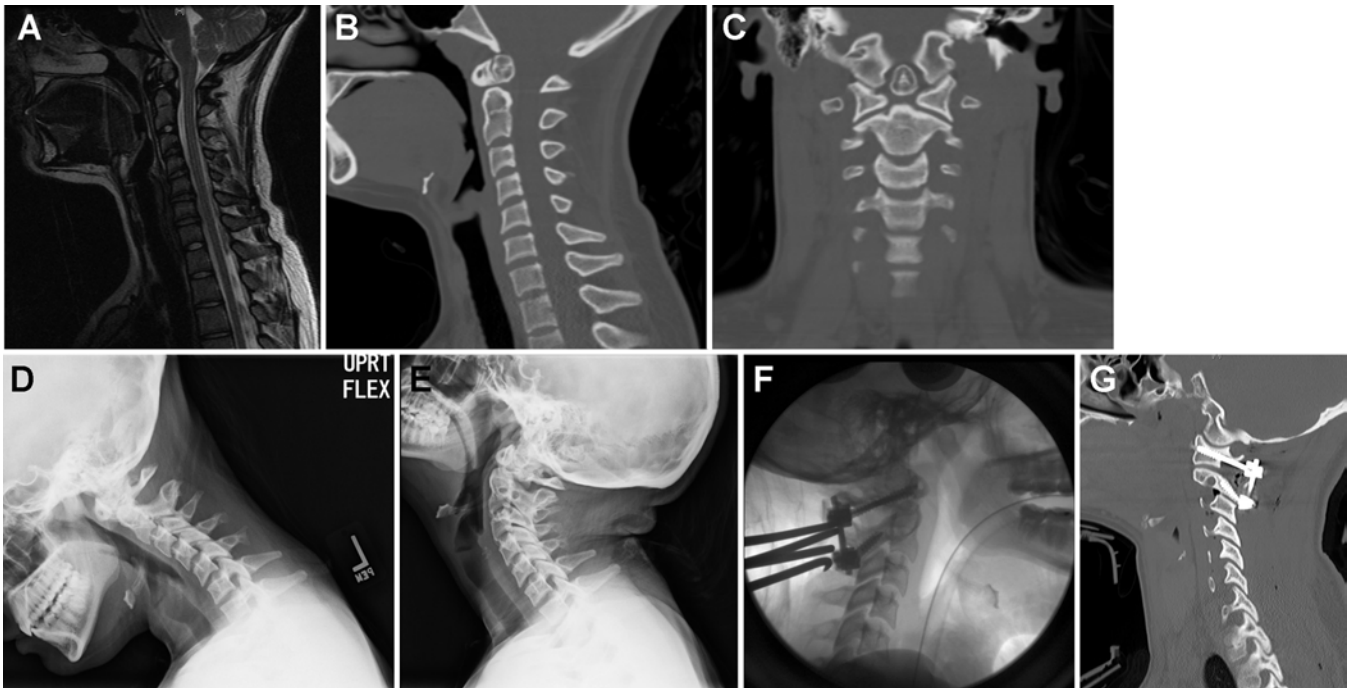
Sagittal T2-weighted MR image (A) and sagittal (B) and coronal (C) CT scans showing a dystopic-type os odontoideum in a 14-year-old girl. On the coronal image, it is clear that the gap between the ossicle and the remainder of the odontoid is above the superior articulating facet of C-2. Flexion radiograph (D) shows no sign of instability, but with extension (E), there is almost 10 mm of subluxation. The patient underwent placement of a Harms construct with bilateral pars interarticularis screws at C-2 coupled to lateral mass screws at C-1. The intraoperative radiograph (F) and postoperative sagittal CT (G) show the position of the hardware. An iliac crest autograft was harvested and secured between C-1 and C-2 after the surfaces were well decorticated.
